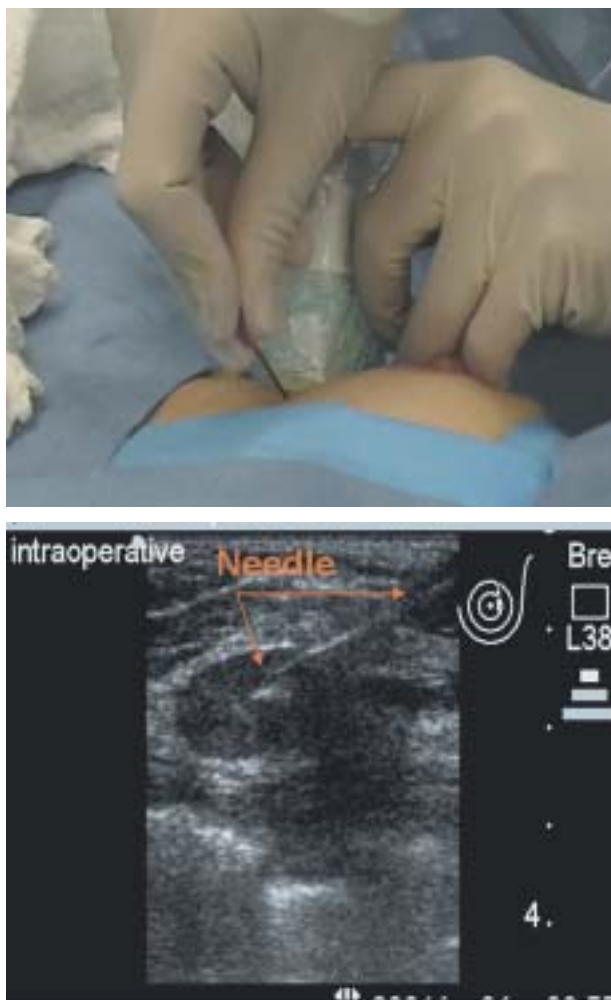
Guided by real-time ultrasound images, the surgeon performs a needle-core biopsy.
